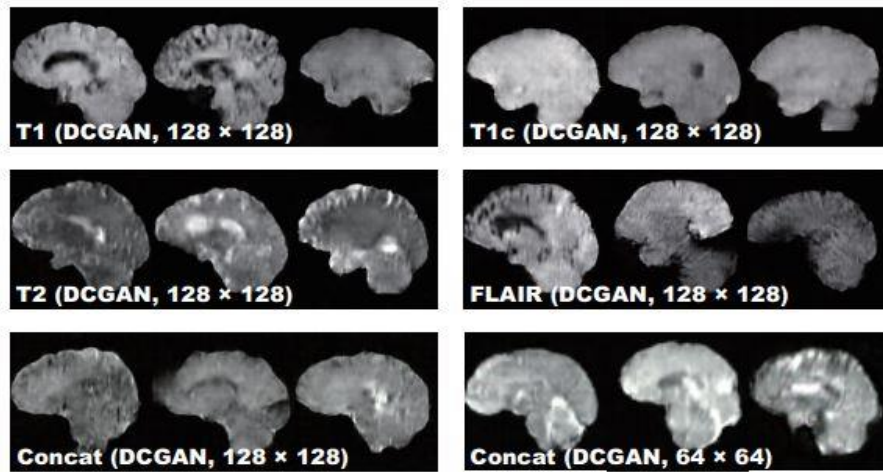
Synthetic MR images based on DCGAN.
